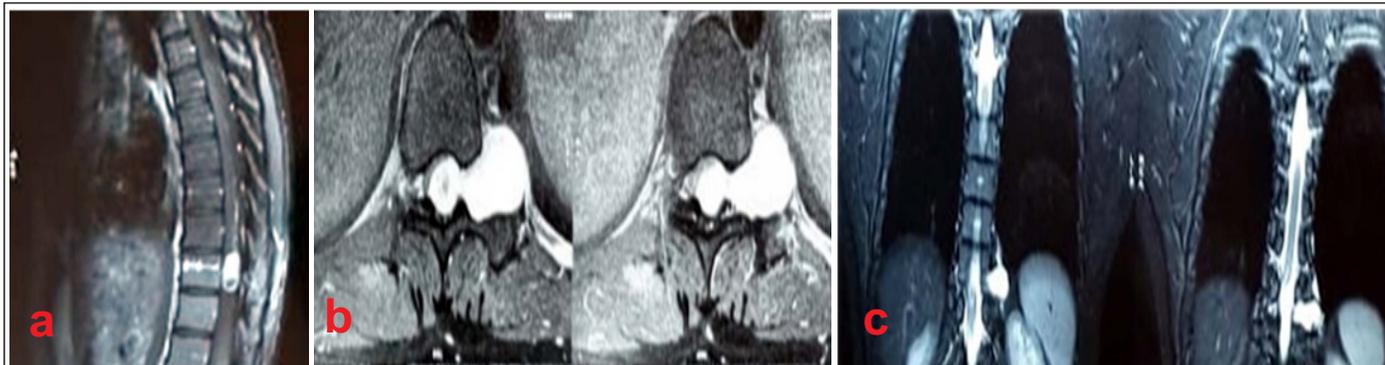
(a) MRI with contrast showing enhancing lesion at level of D10. (b) MRI with contrast axial section showing homogeneously enhancing left-sided lesion, intradural with extradural extension producing dumbbell-shaped morphology. Spinal cord pushed toward the right side. (c) MRI with contrast scan coronal view showing lesion arising from D10-11 level on the left side.
